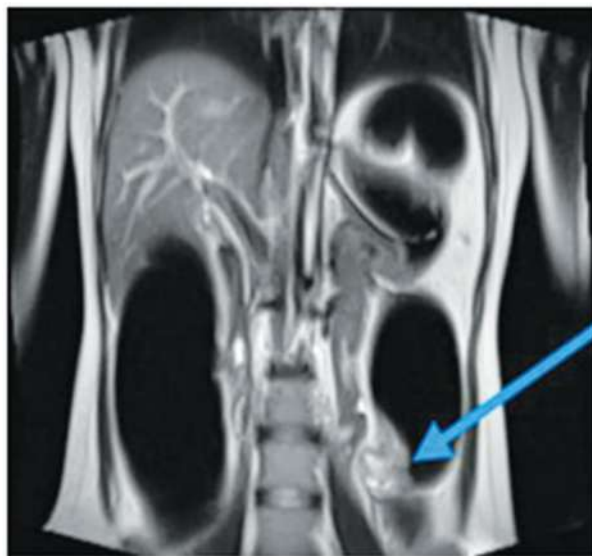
MRI abdomen showing growth in descending colon.
